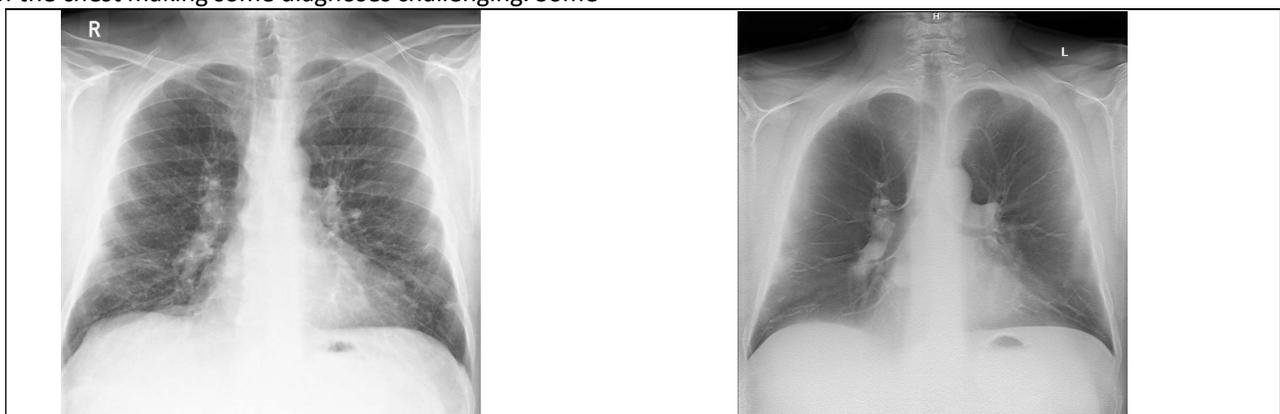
With a normal chest X-ray (left), the 2D nature of the image can mean that details in the lungs are obscured by overlying ribs and collar bones. A slice through a 3D tomosynthesis volume (right) shows internal anatomical details in the chosen plane with much greater clarity
